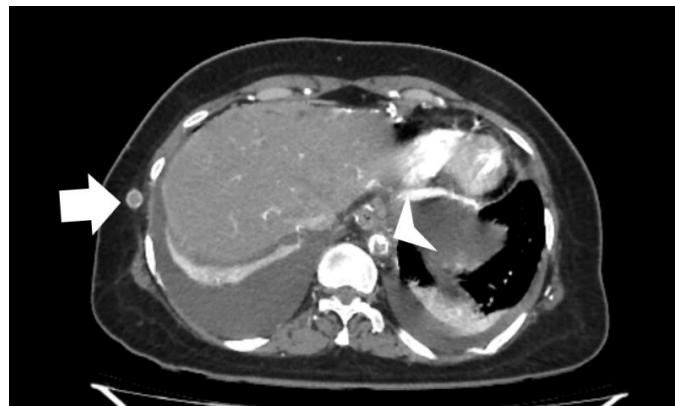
Axial section of CT aortogram showing thrombosis of axillo iliac graft
